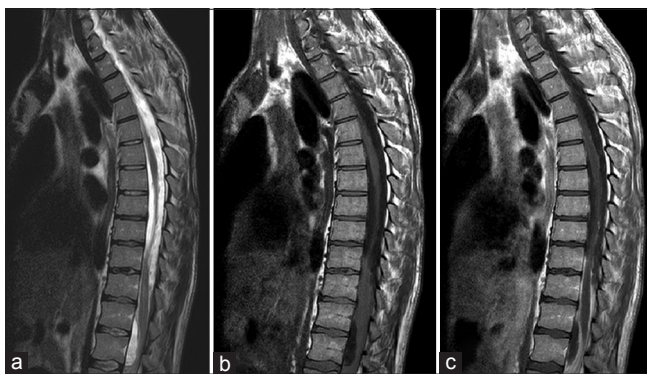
(a) T2 sagittal MRI: extensive loculated fluid collections compressing the spinal cord ventrally at T12-L2 and dorsally at T8-T12 level. Note T2 cord signal change within the distal thoracic cord/conus at T11-T12. (b) T1 sagittal MRI without contrast: anterior displacement of the cord from T9-T12 level. (c) T1 Sagittal MRI with contrast: distinct enhancement of the fluid collections at T8-T12, T12-L2 and leptomeninges/nerve roots in the cauda equina
